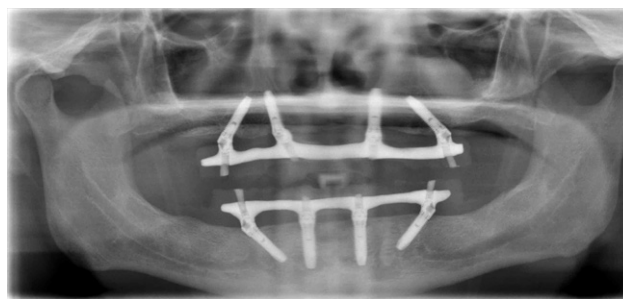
Orthopantomography representative of a patient with a bimaxilar rehabilitation through the All-on-4 concept with 5 years of follow-up (patient from Figures 1 and 2).
